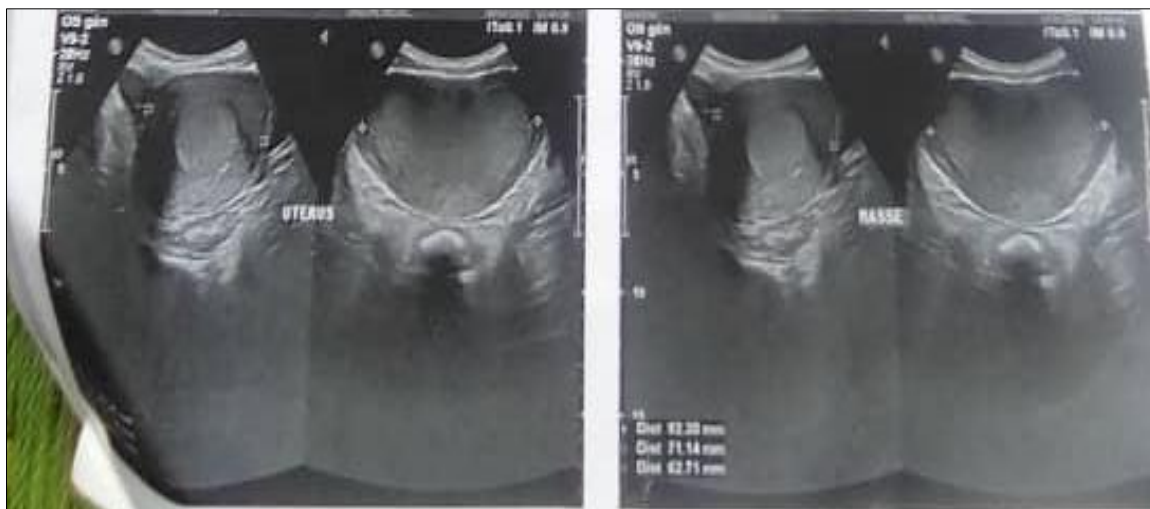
Ultrasound Images (Sagittal And Axial Sections of the Uterus Showing a Thickened Endometrium, Absence of Isthmic Image, Absence of Cervix And Vaginal Canal).
